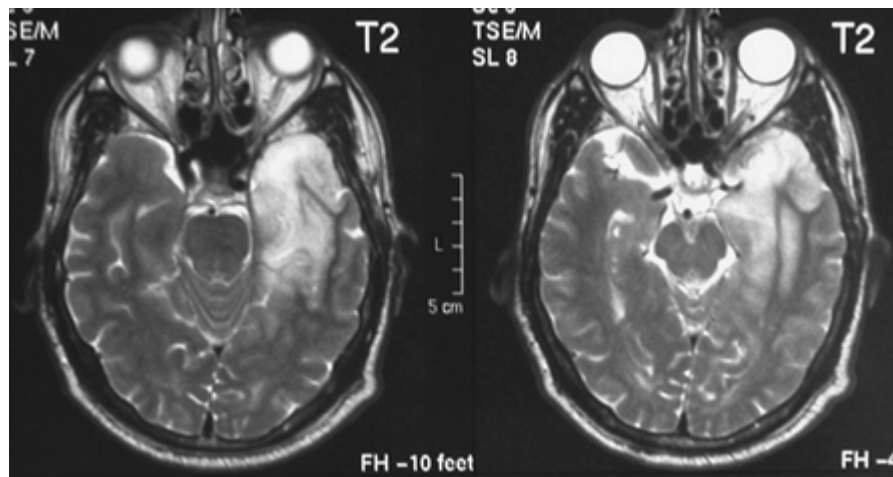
T2-weighted MRI of patient with herpes simplex virus type 1 encephalitis showing hyperintense lesion in left temporal lobe.
